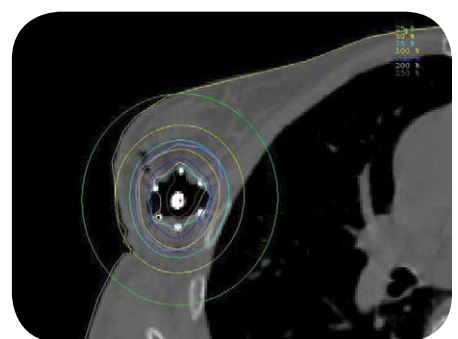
CT image of 6-1 SAVI applicator implanted into lumpectomy cavity
